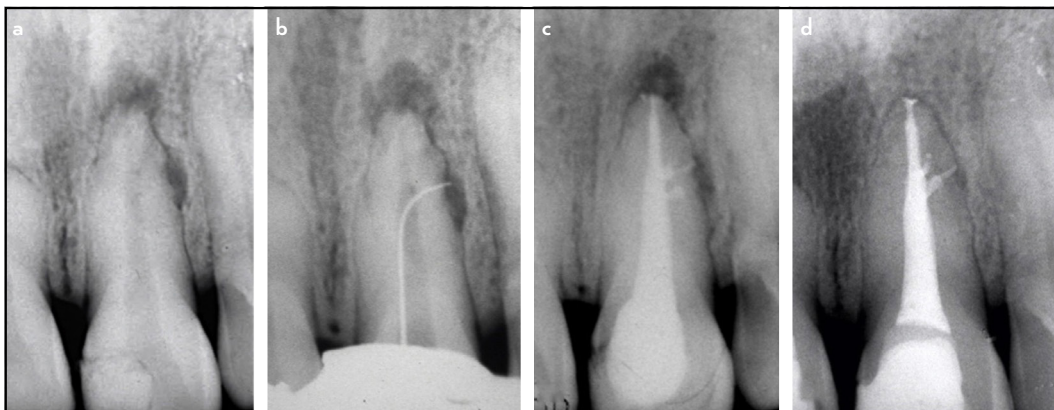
Case 4, tooth 11, necrotic pulp with apical periodontitis. (a) initial; (b) instrument in the lateral canal; (c) after root canal filling; and (d) 3-year follow-up radiographs
